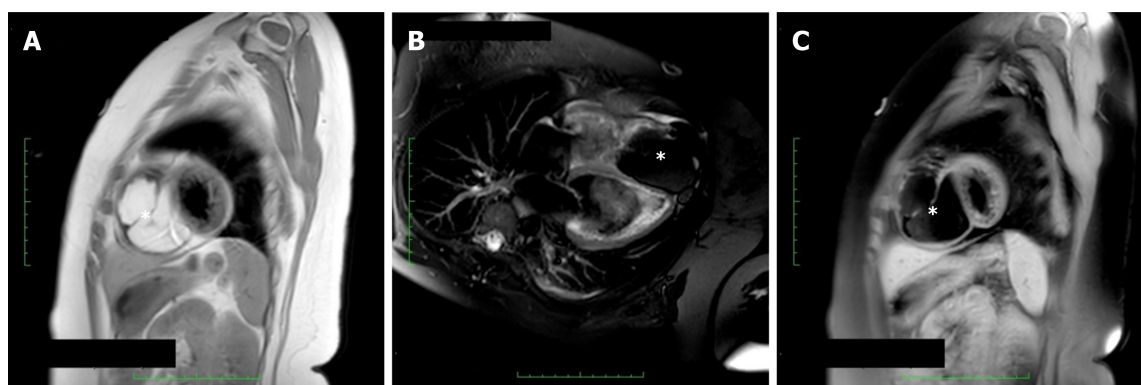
Cardiac magnetic resonance. A: A right ventricular mass (star) appearing white in T1-weighted sequence; B: Dark (star) in T2-weighted sequence; C: A dark signal (star) dropout in T1-weighted fast spin-echo sequences.
